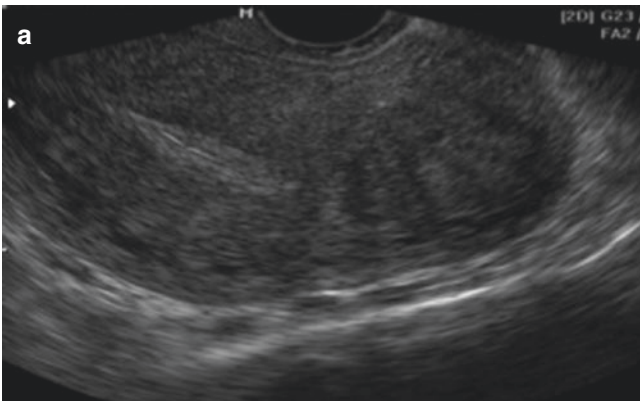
Transvaginal oblique image of the uterus with a myoma on the fundus. (a) Grayscale shows focal hypoechoic circumscribed nodule. (b) Color Doppler sonogram shows vessels at the margin of the lesion
